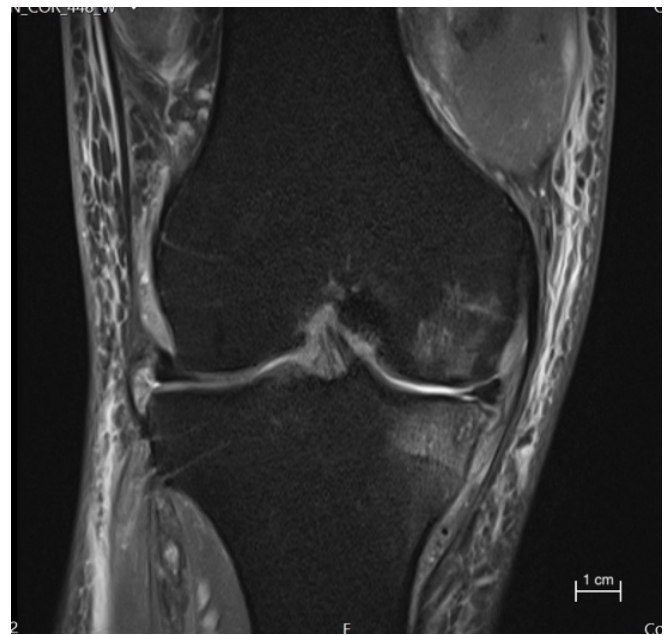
Magnetic resonance imaging of a 59-year-old male patient with knee osteoarthritis. This coronal STIR image demonstrates focal subchondral bone edema-like lesion in the medial femoral condyle and tibia.
